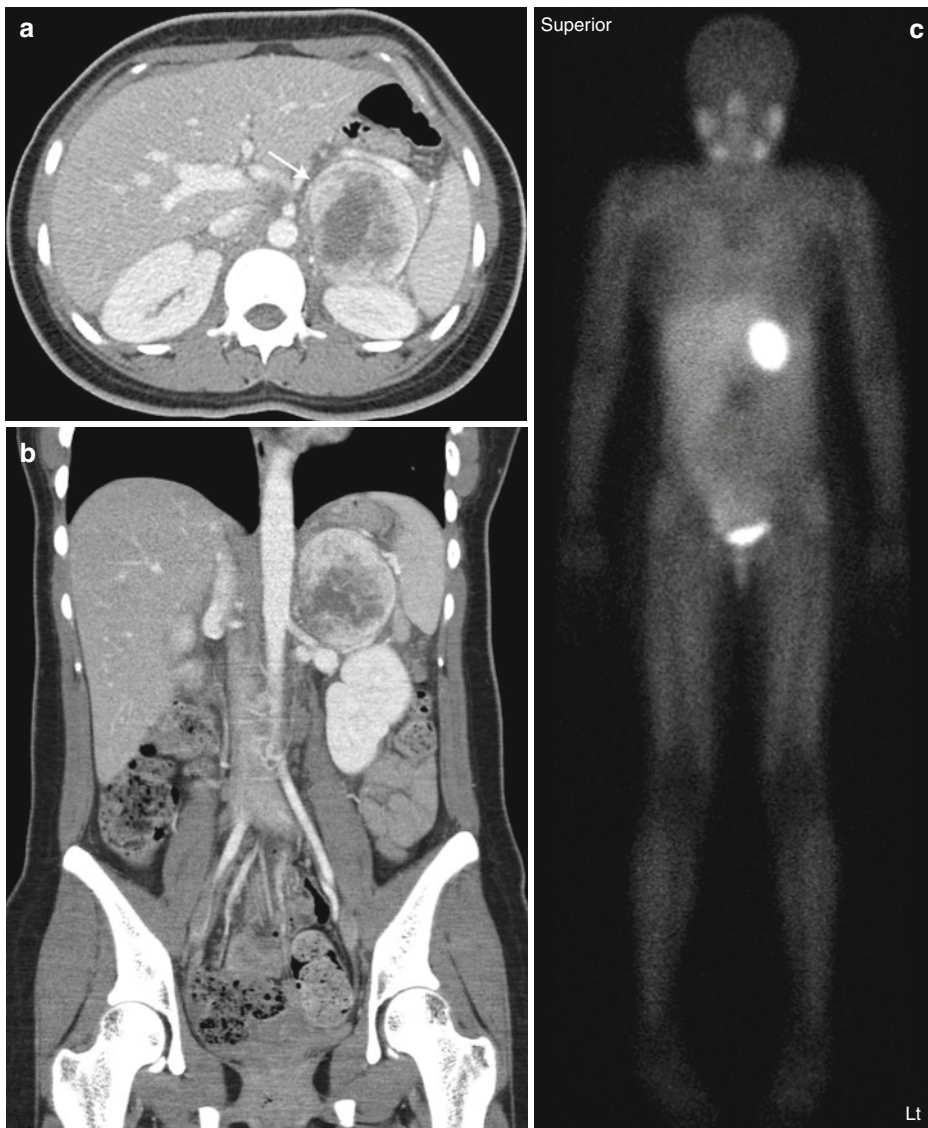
Pheochromocytoma. Axial (a) and coronal (b) contrast-enhanced CT images and MIBG scan (c) performed in a teenage girl with history of tachycardia and hypertension
